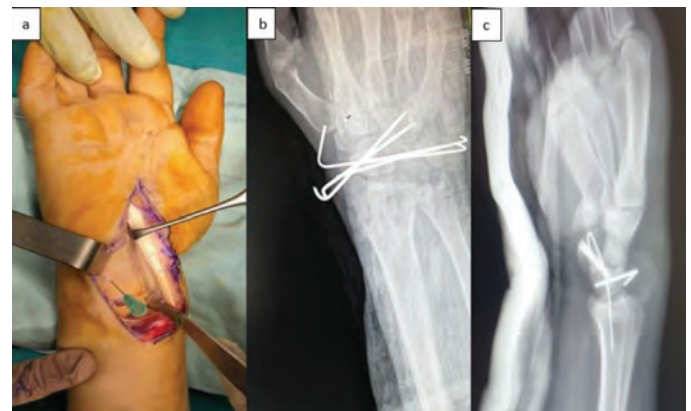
(a) Stage 3 perilunate injury treated with the volar approach and (b, c) postoperative X-ray images
